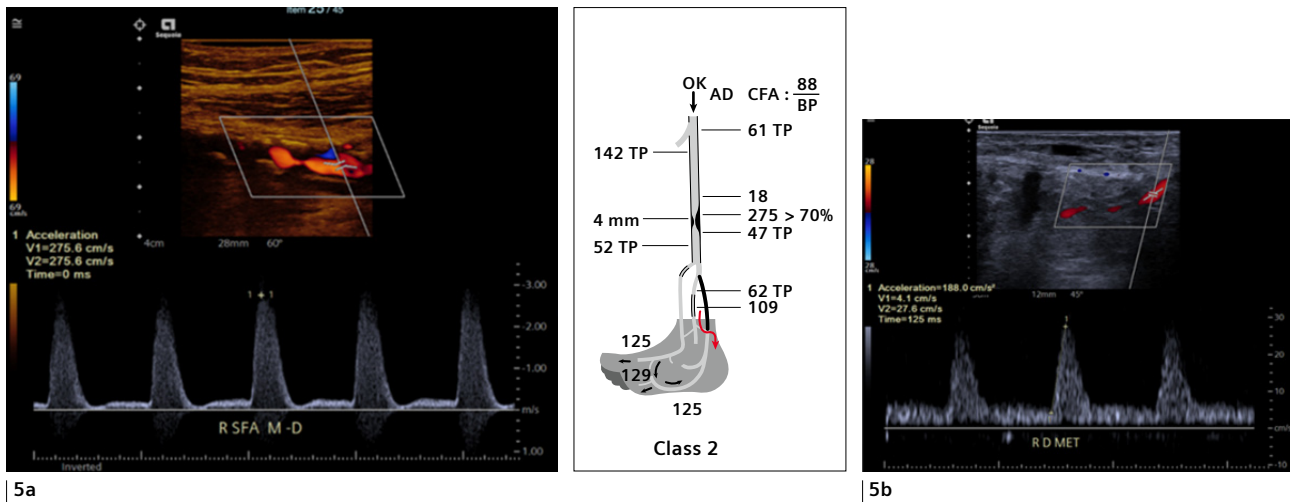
One-month follow-up ultrasound showing class 2 PAT with healed wounds. Greater than 70% stenosis in the superficial femoral artery (5a), and pedal acceleration time (PAT) to the wound bed demonstrating class 2 perfusion (5b).
